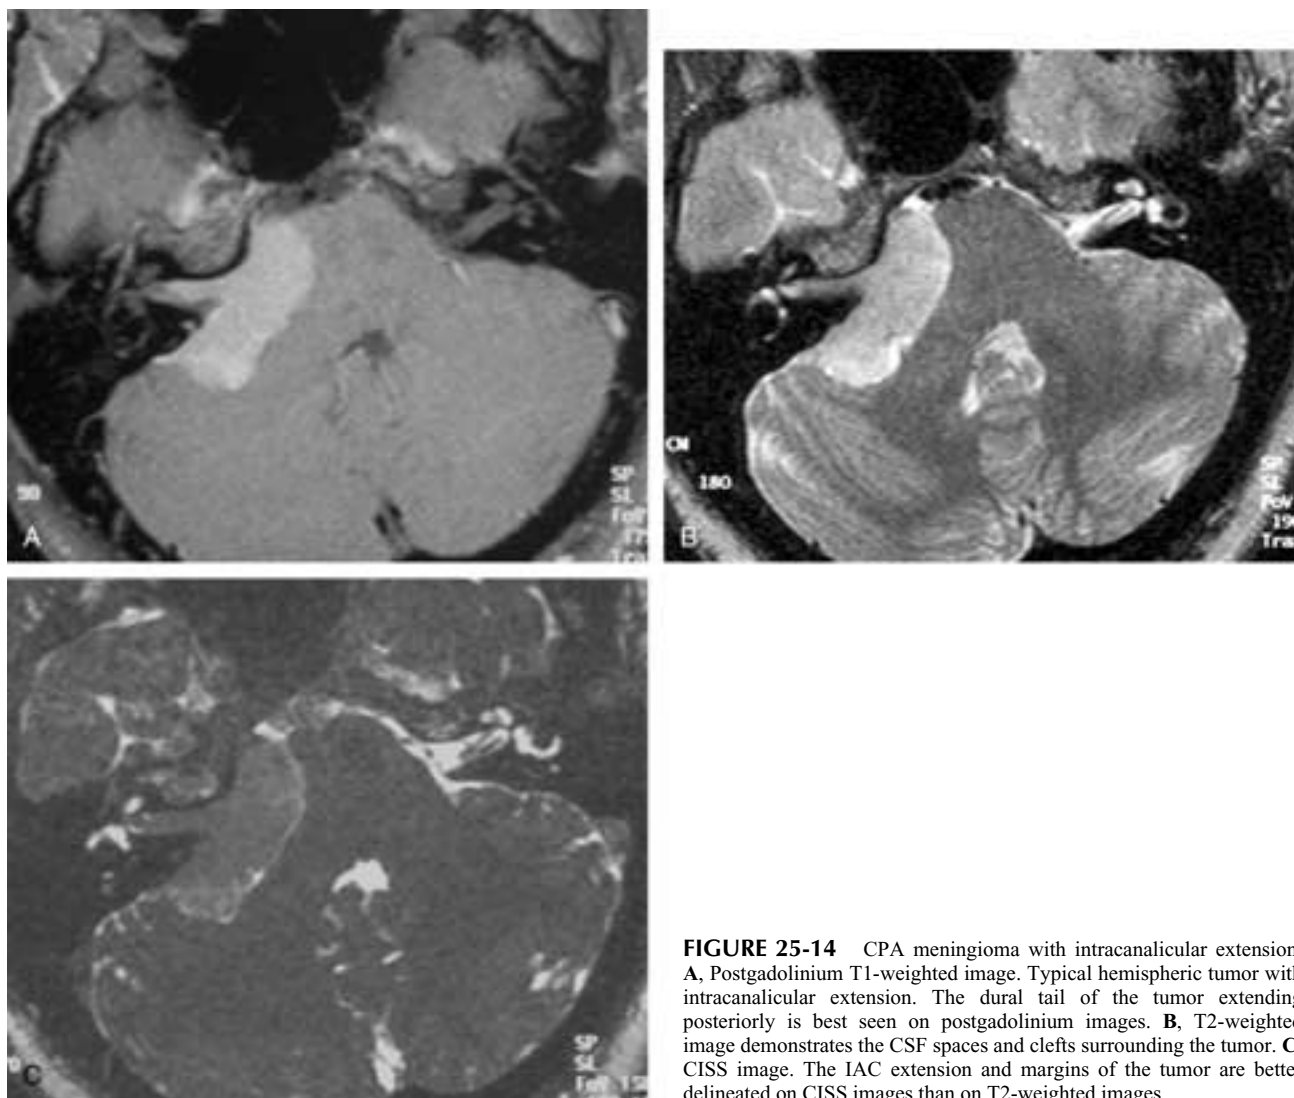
CPA meningioma with intracanalicular extension. A, Postgadolinium T1-weighted image. Typical hemispheric tumor with intracanalicular extension. The dural tail of the tumor extending posteriorly is best seen on postgadolinium images. B, T2-weighted image demonstrates the CSF spaces and clefts surrounding the tumor. C, CISS image. The IAC extension and margins of the tumor are better delineated on CISS images than on T2-weighted images.
